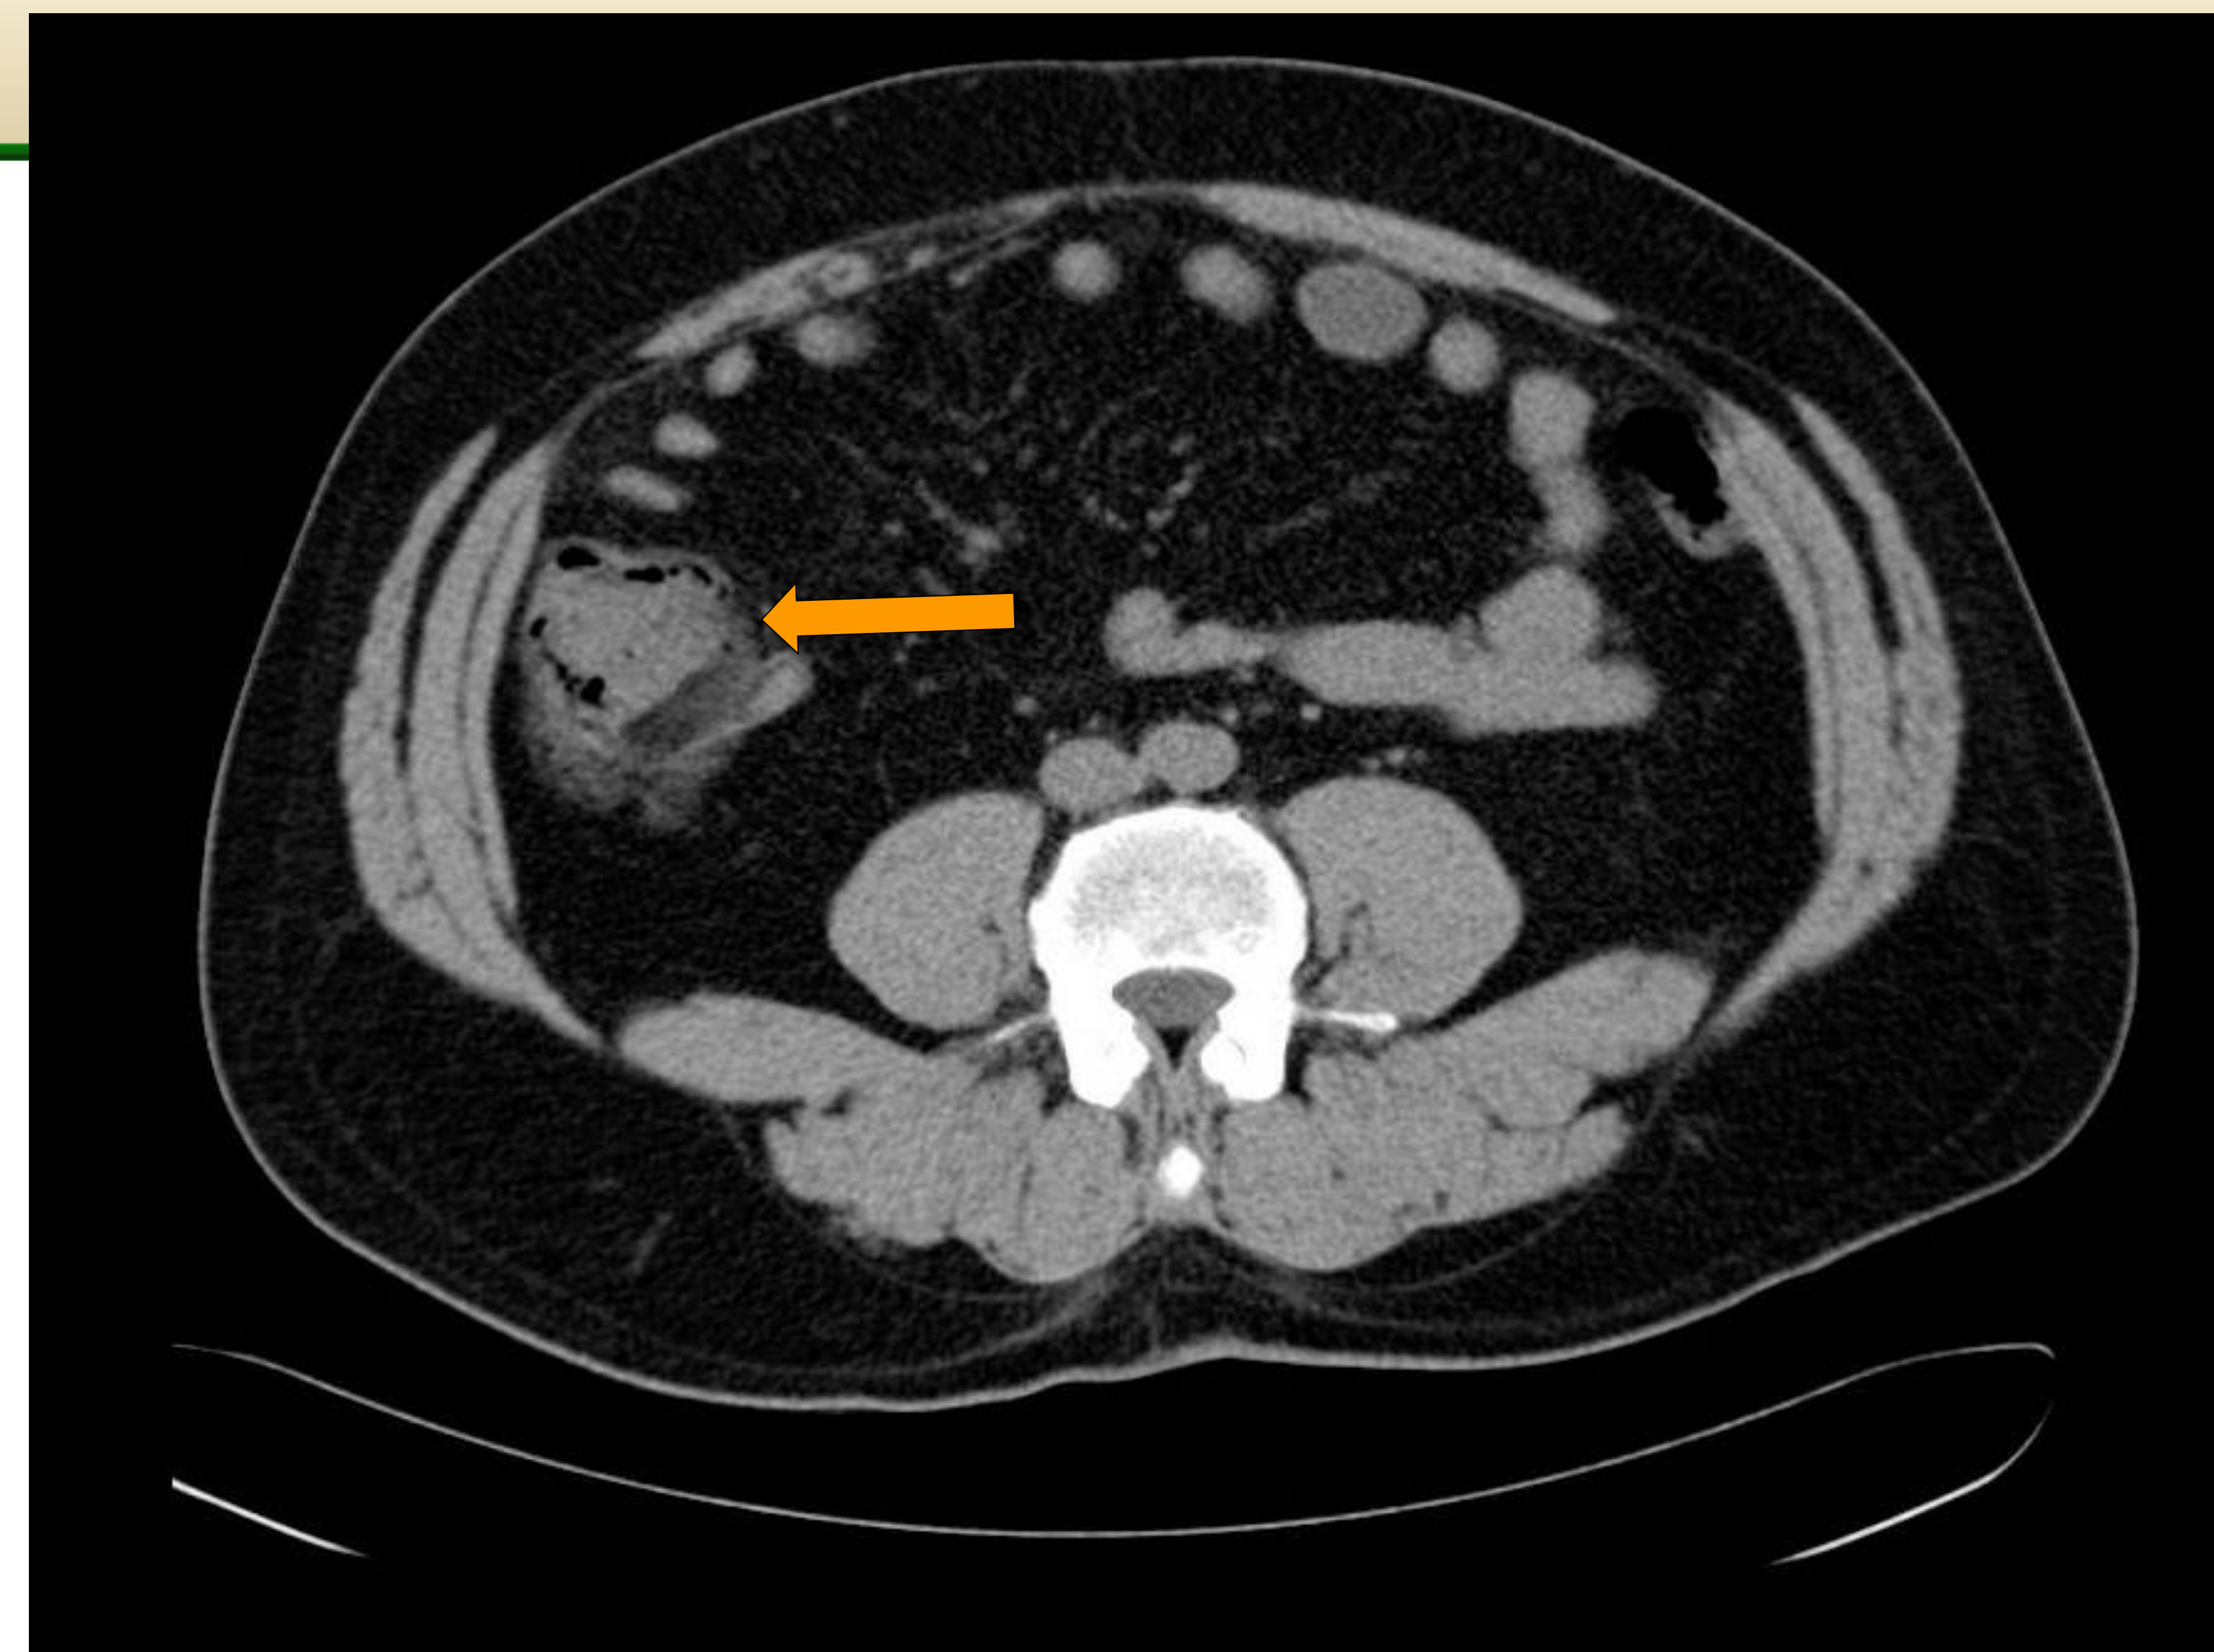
Abdominal CT Scan with evidence of localized fat stranding and edema in the hepatic flexure and proximal half of transverse colon.
